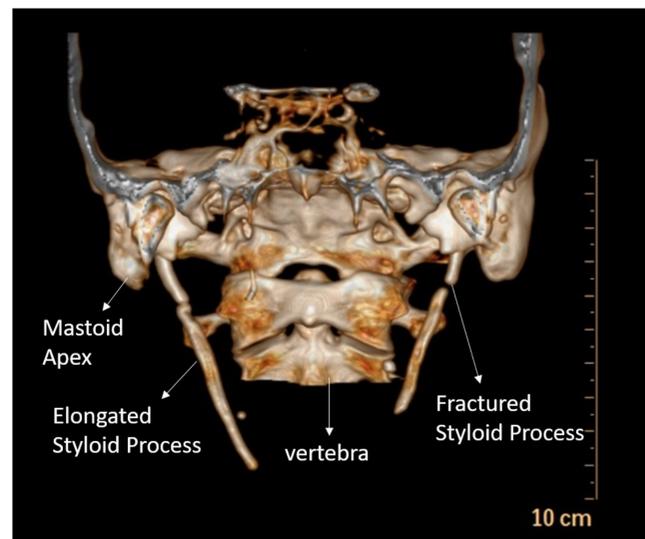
Preoperative 3D-CT scan being used to evaluate styloid process length, thickness and fracture features
